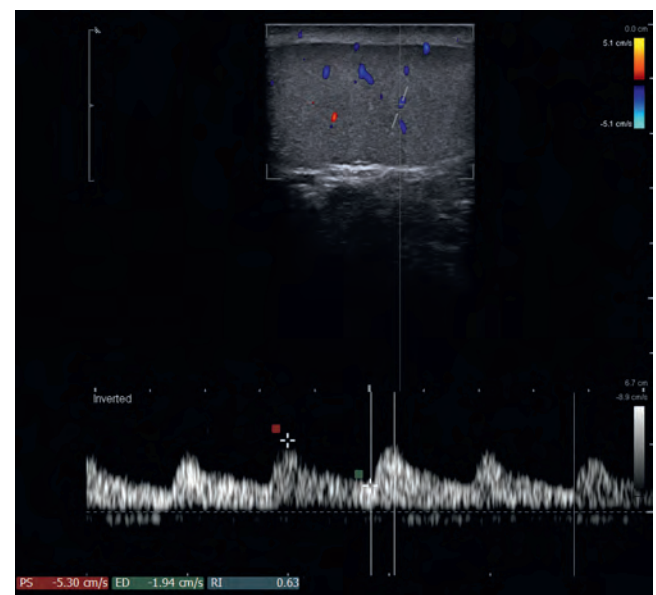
Spectral Doppler analysis of an intratesticular artery demonstrating a peak systolic velocity of 5.3 cm/sec, an end-diastolic velocity of 1.94 cm/sec, and a calculated resistive index of 0.63 in a patient with dyspermia.
